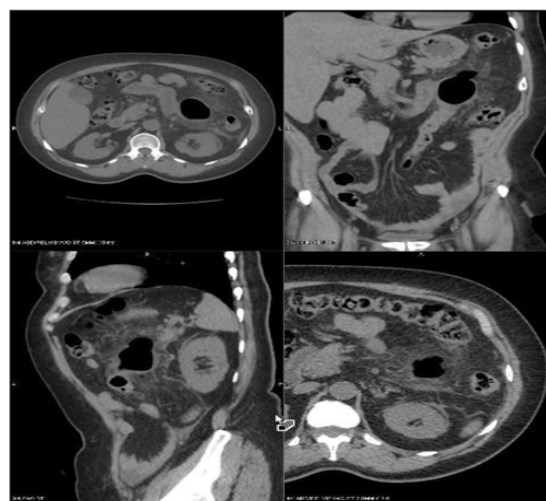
CT of the diverticulum in axial, coronal and sagittal imaging of giant diverticulum at original presentation.
